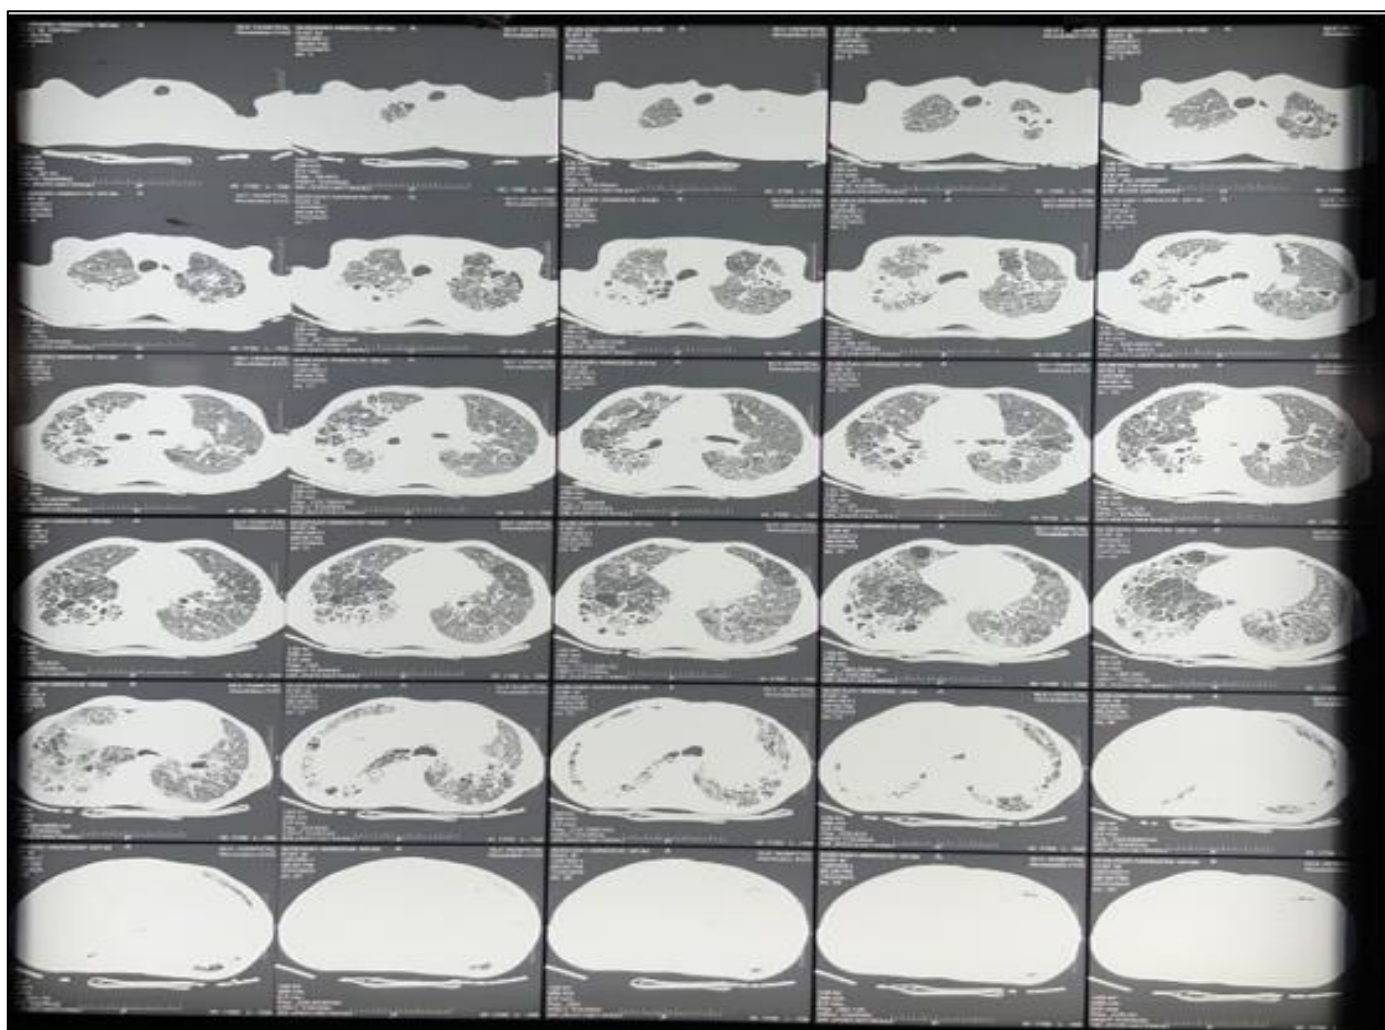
HRCT revealed diffuse fibrotic changes with traction bronchiectasis throughout both lungs along with areas of fibrocavitary changes in the upper lobes. There were patchy consolidations and small airspace nodules in both the lungs and branching centrilobular nodular opacities (“tree-in-bud” pattern) diffusely especially in the right upper lobe.
